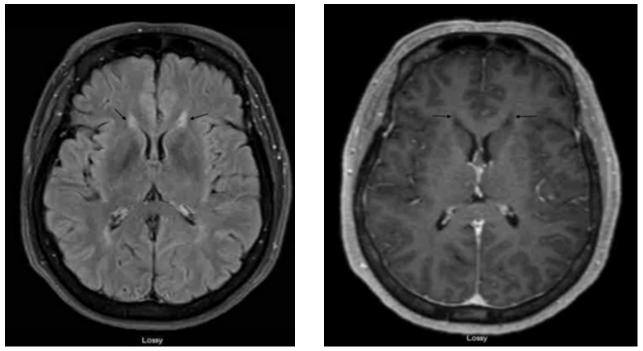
Axial FLAIR (A), axial T1 (B) MRI brain showing characteristic signal abnormalities involving forceps minor region of genu of corpus callosum (arrows) resembling the Ear of the Lynx sign.
